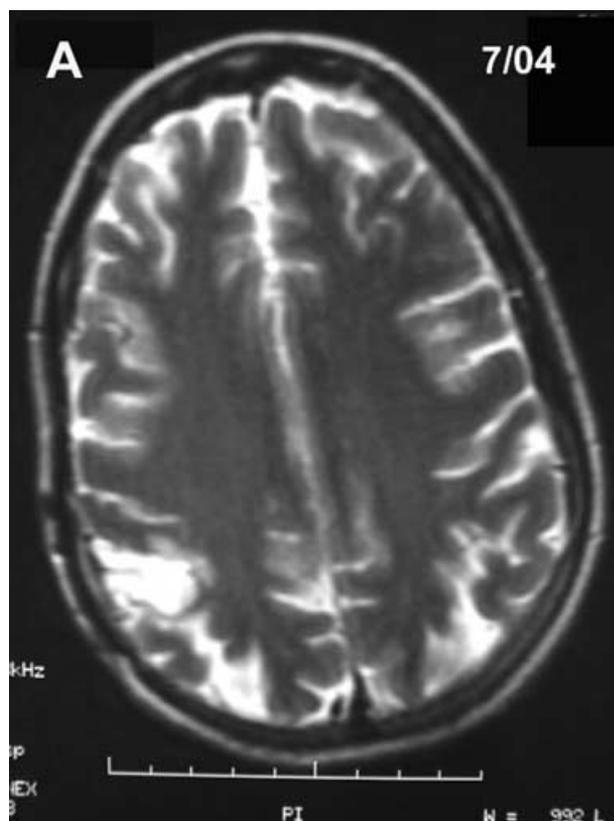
Postoperative brain MRI of Patient 1. A) Axial T₂-imaging reveals the resection cavity with adjacent increased signal suggestive of postoperative gliosis and normalization of signal in the residual primary sensory cortex anterior to the cavity. B) Axial FLAIR images showing the same normalization.
